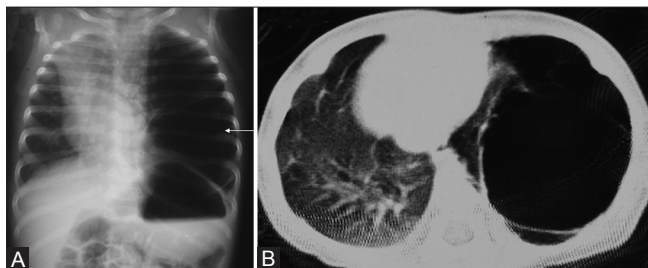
(A, B): A 3-month-old infant with respiratory distress. (A) Chest radiograph shows cystic hyperlucent left lung field with septations (arrow) and mass effect. This was mistaken as pneumatocele with resultant chest tube insertion. (B) CT chest axial section with lung window shows a thin-walled cyst in left lower lobe with mass effect. Diagnosis was confirmed after surgery as type 1 CCAM
